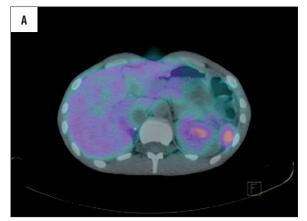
PET-CT scan with 18F-FDG of patient D.K. from 29 November 2010 with suspected accessory spleen near the left kidney.
